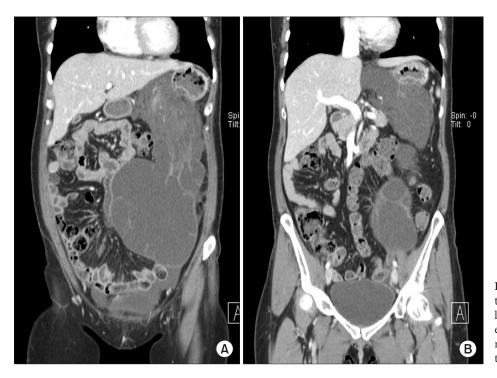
Findings of the computed tomography analysis. (A) A multilobulated cystic mass was observed to extend into the pelvic cavity. (B) This mass originated from the lesser omentum, including the truncal vagus.
